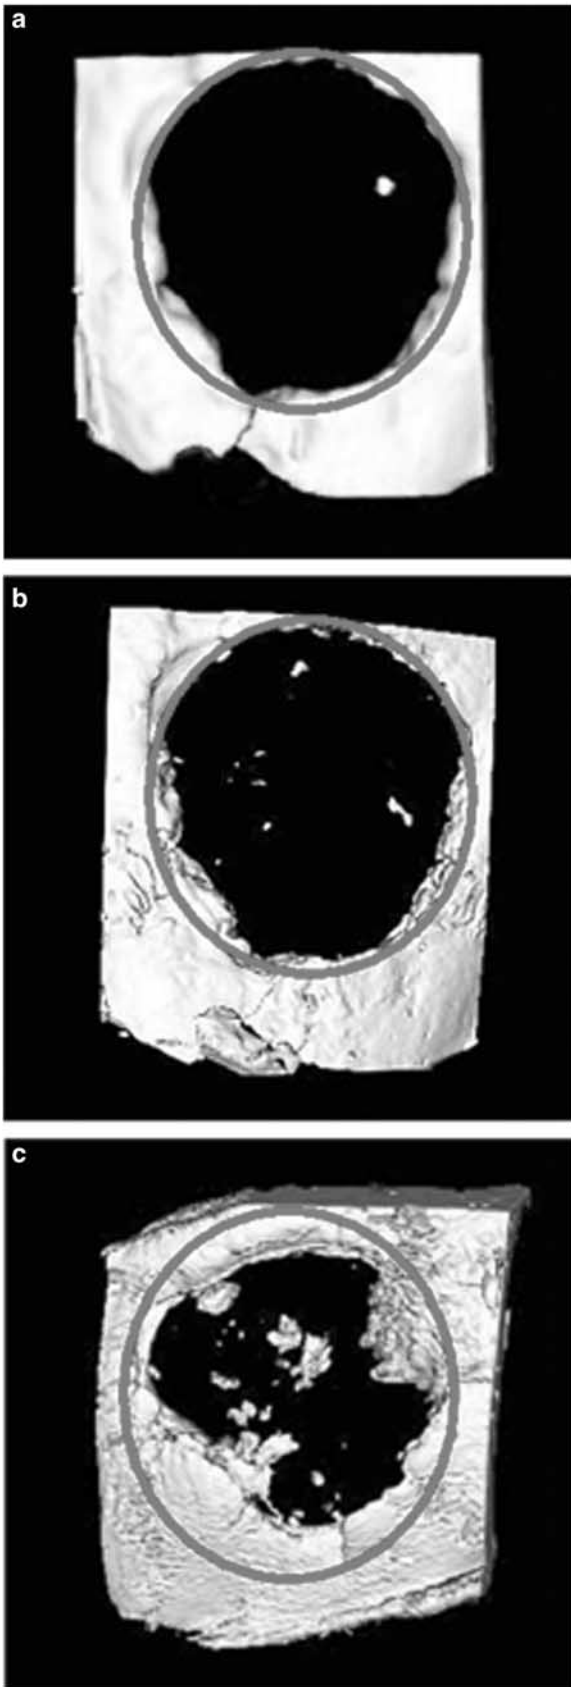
Three-dimensional μ CT images of (a) blank scaffold, (b) scaffold encapsulating plasmid DNA, (c) Scaffold encapsulating condensed plasmid DNA at 15 weeks. Image reconstructions were performed at a resolution of 18 μ m. The circles indicate the cranial defect edges.
